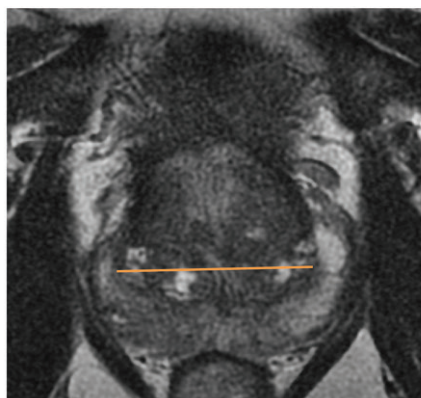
Axial (a, c) and sagittal (b, d) T2-weighted MR images in a 70-year-old man show calculation of the whole prostate volume and the central gland volume (central zone plus transitional zone). The prostate dimensions in this patient are $6.7 \times 4.7 \times 5.6$ cm, with a whole prostate volume of 92 cm^3 , central gland volume (central zone plus transitional zone) of 45 cm^3 , and zonal volumetry index of 0.49.
